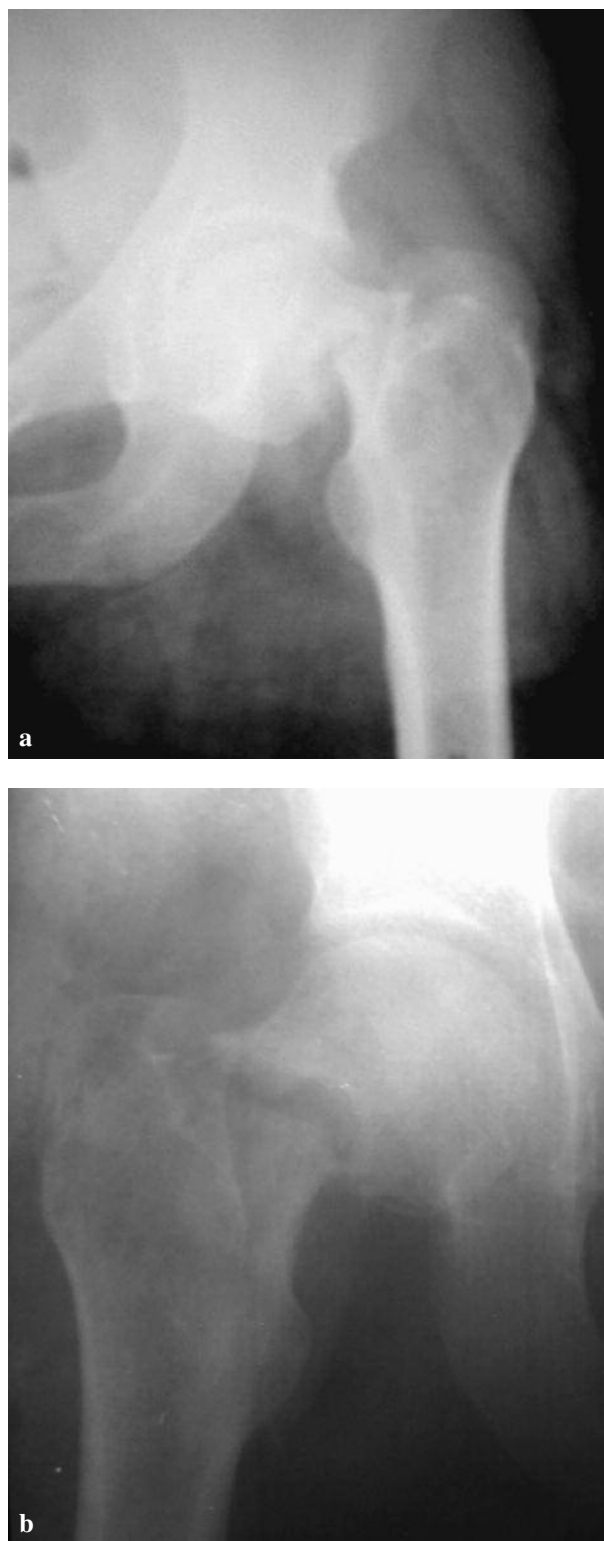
a & b. — Preoperative pelvic AP roentgenogram showing bilateral Garden type-3 fracture of the neck of the femur.
